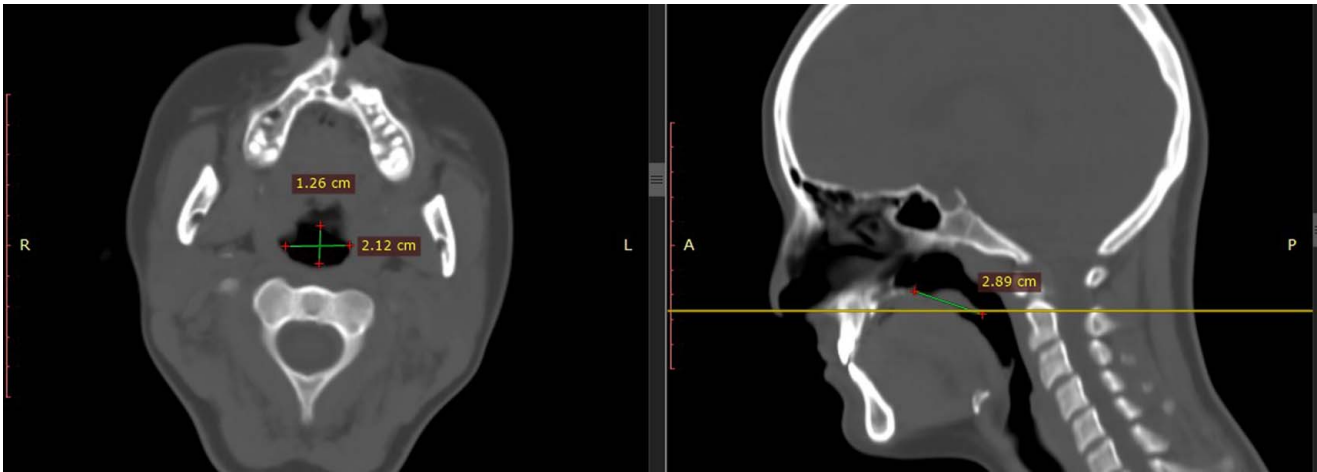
Radiographic measurement of velopharyngeal port at the level of the incisive foramen that demonstrates the anterioposterior and mediolateral distances 12 months after surgery.
